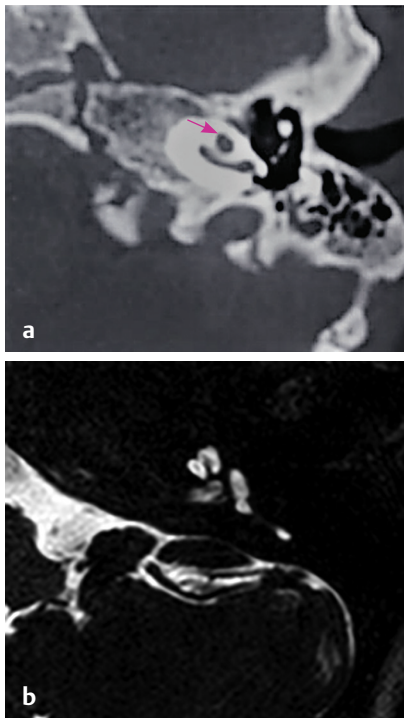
(a) HRCT temporal bone, bone window and pink arrow points towards fewer number of turns of cochlea. (b) MRI CISS sequence, axial section shows CH3.
